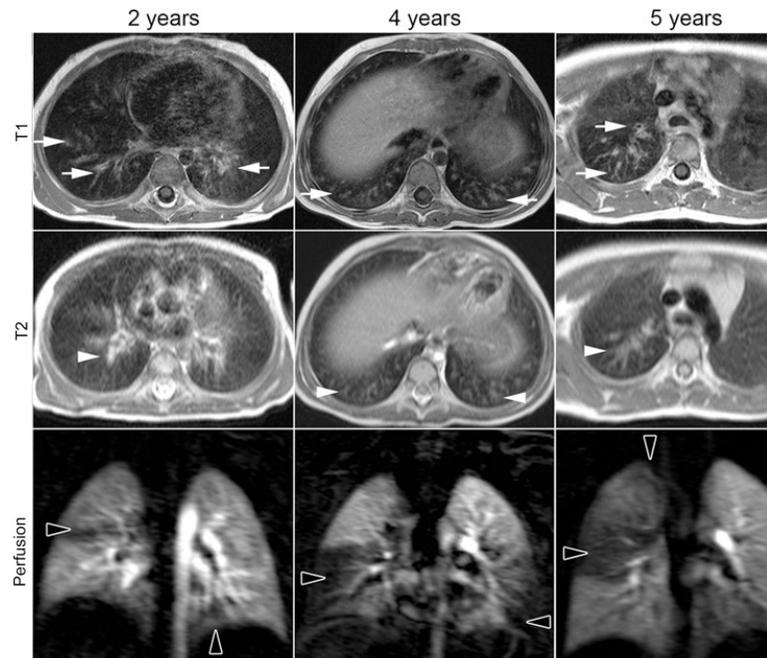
from: Wielpütz MO, et al. Magnetic resonance imaging detects changes in structure and perfusion, and response to therapy in early cystic fibrosis lung disease. *Am J Respir Crit Care Med.* 2014;189(8):956-965; reprinted with permission.
